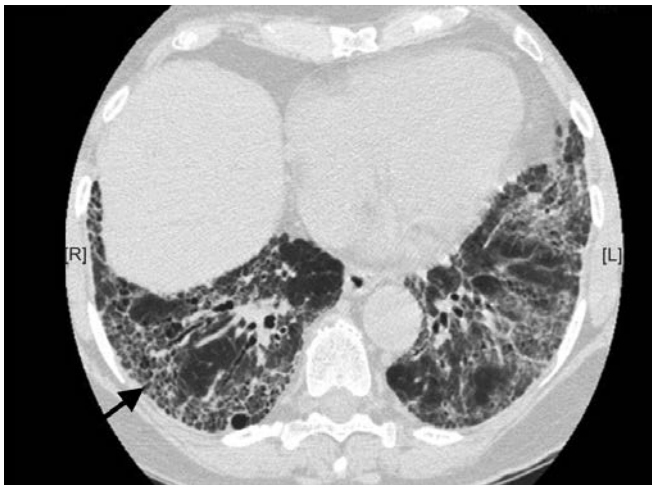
HRCT through the lower lung zones showing honeycombing (arrow) with dilated non-tapering bronchi especially on the right side (traction bronchiectasis) and architectural distortion
